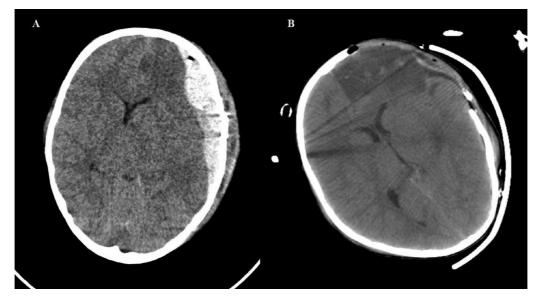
Noncontrast CT head showing (A) left frontotemporoparietal EDH with fracture of the left temporal bone. (B) Left FTP DC.
